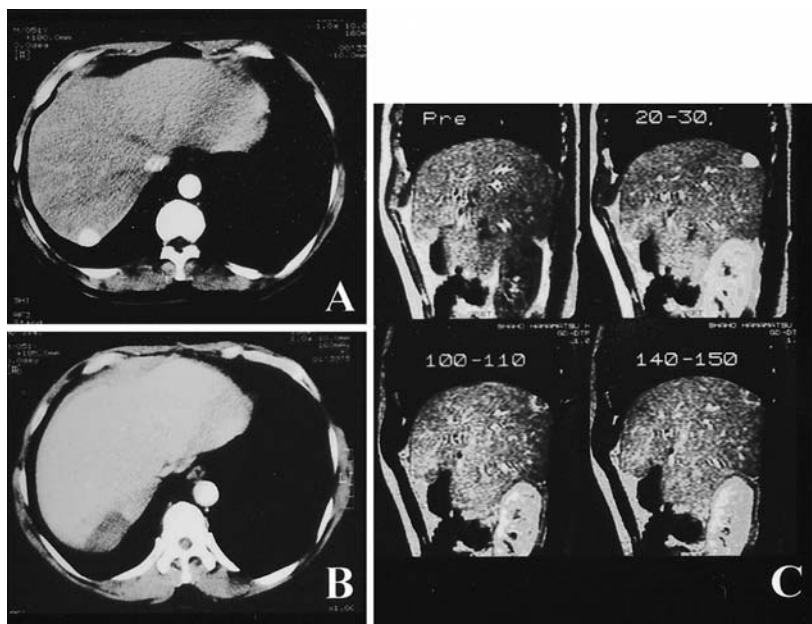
A Preoperative computed tomography (CT) shows a low-density well-enhanced mass, 20mm in diameter, in the upper part of the right posterior segment. B CT at 10 months after operation demonstrates a coagulated site, which can be seen as a nonenhanced area; the hepatocellular carcinoma lesion is completely coagulated. C Preoperative magnetic resonance imaging (MRI) of sagittal view shows an isodensity mass, which is ring-enhanced in the late phase with intravenous bolus injection of contrast medium
